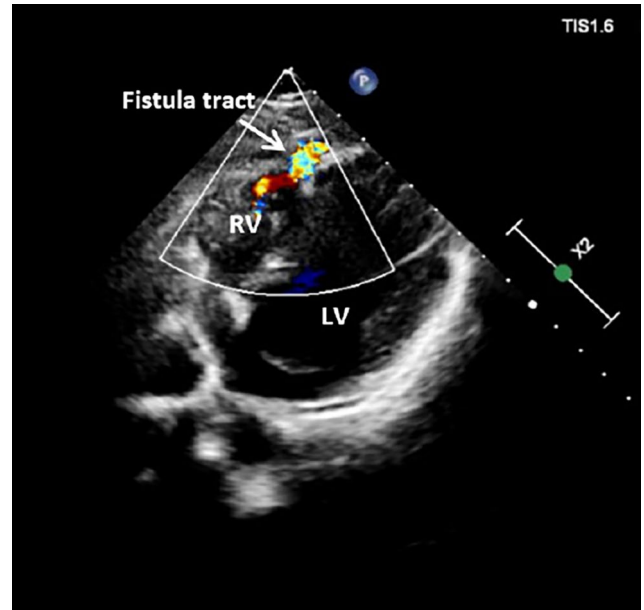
An echocardiographic view shows a coronary fistula originating from the anterior aspect of the right ventricle and draining into the hypoplastic right ventricle.
